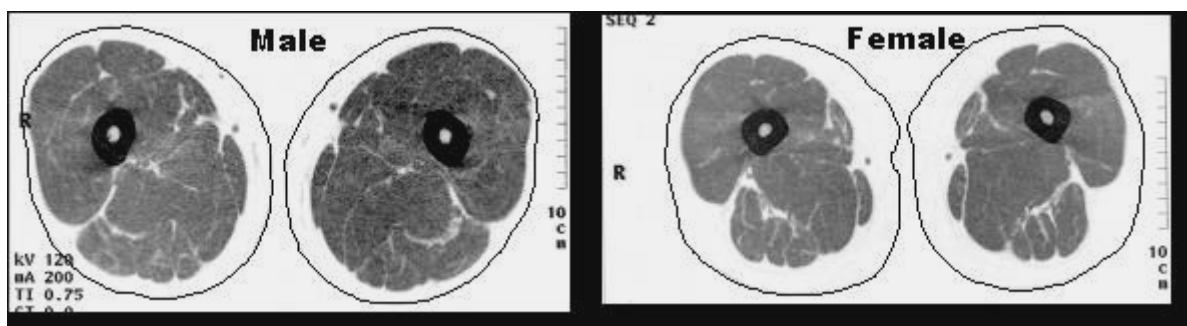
Examples of CT scan analysis from a male and a female subject.
